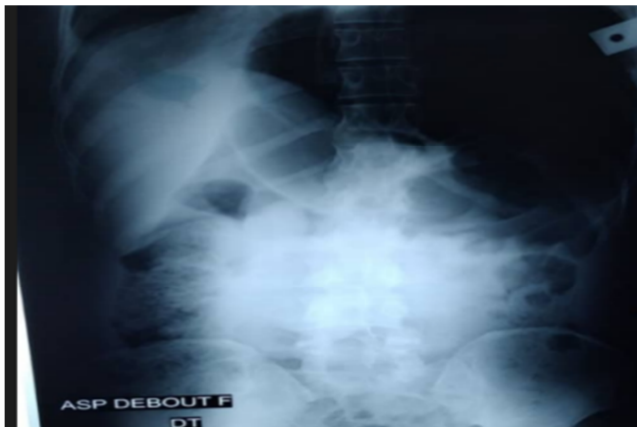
X-ray of the abdomen showing a gaseous hyperclarity.
